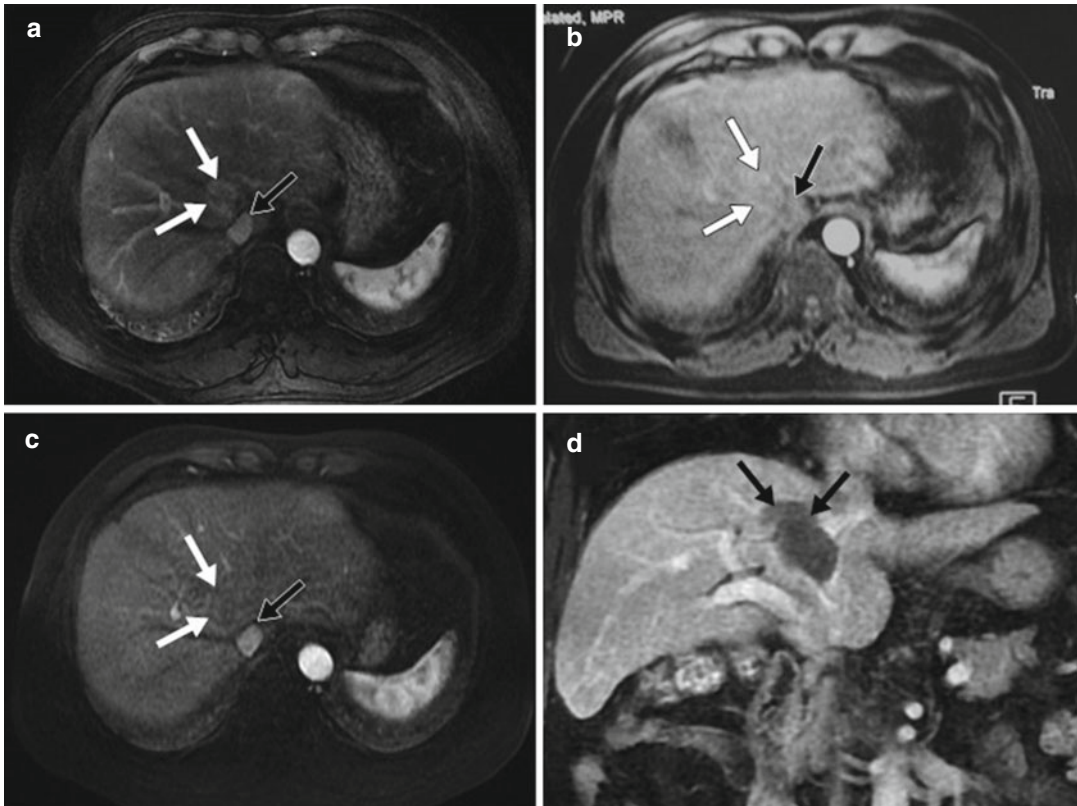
Contrast-enhanced magnetic resonance imaging (MRI) of a 48-year-old man shows a 4.1×3.4 cm nodule of hepatocellular carcinoma (HCC) adjacent to the inferior vena cava (black arrows in b and c) treated by microwave ablation (MWA). (a) Preablation image shows one neoplasm (white arrows) adjacent to the inferior vena cava
